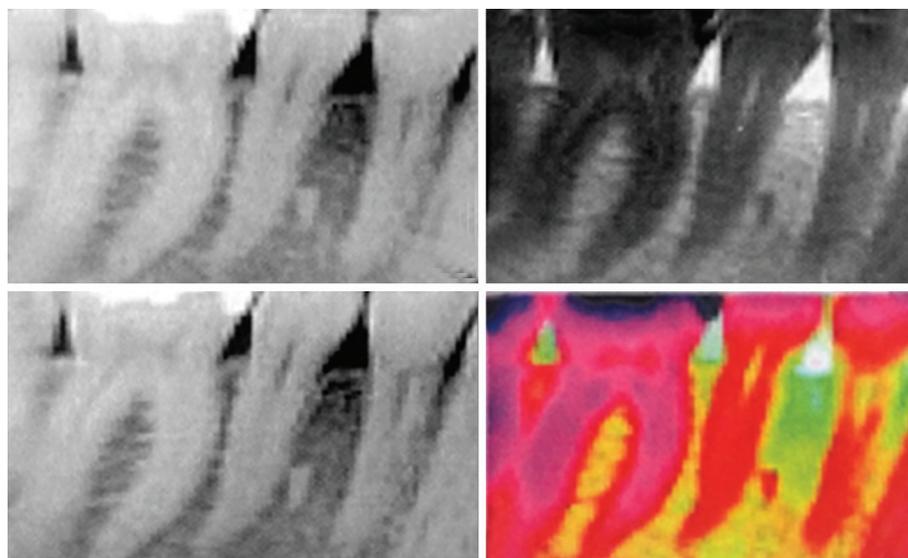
Radiographs evaluated with DentalEye software program and its filters
